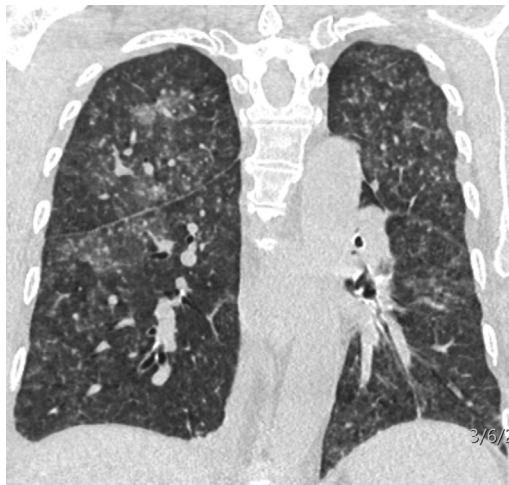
CMV in a 62-year-old female with a history of orthotopic heart transplant for non-ischemic cardiomyopathy. Her CMV prophylaxis was stopped early on posttransplant due to thrombocytopenia/anemia. Coronal chest CT demonstrates diffuse bilateral nodules with mild peribronchovascular ground-glass opacities. (Courtesy of Farouk Dako, MD, MPH, Philadelphia, Pennsylvania.).
